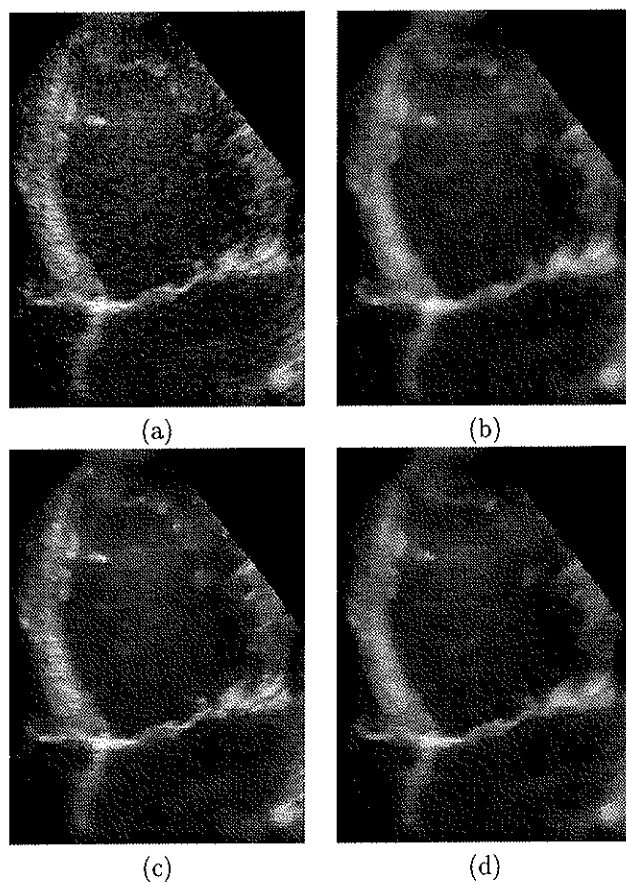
Ultrasound image of the heart. (a) The original image. (b) Median filtered. (c) Anisotropic diffusion filtered. (d) FNR filtered.
